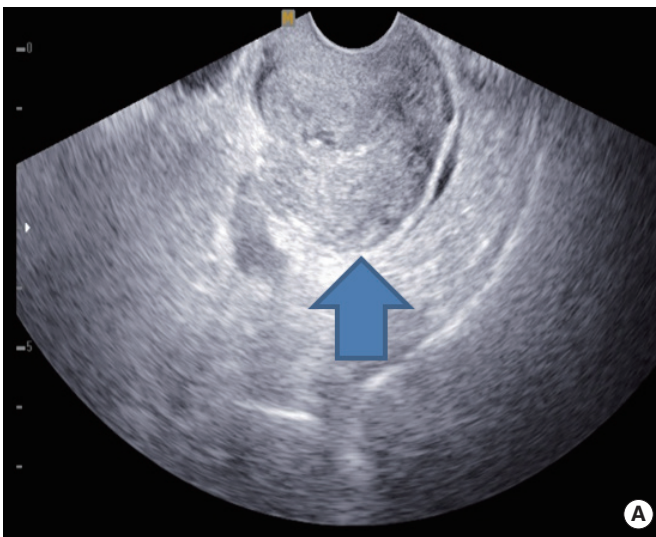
The patient had a normal cuff (arrow) one month postoperatively (A), but a 61 × 53 mm abscess (arrow head) on the cuff two months after laparoscopic supra-cervical hysterectomy on transvaginal ultrasonography.
